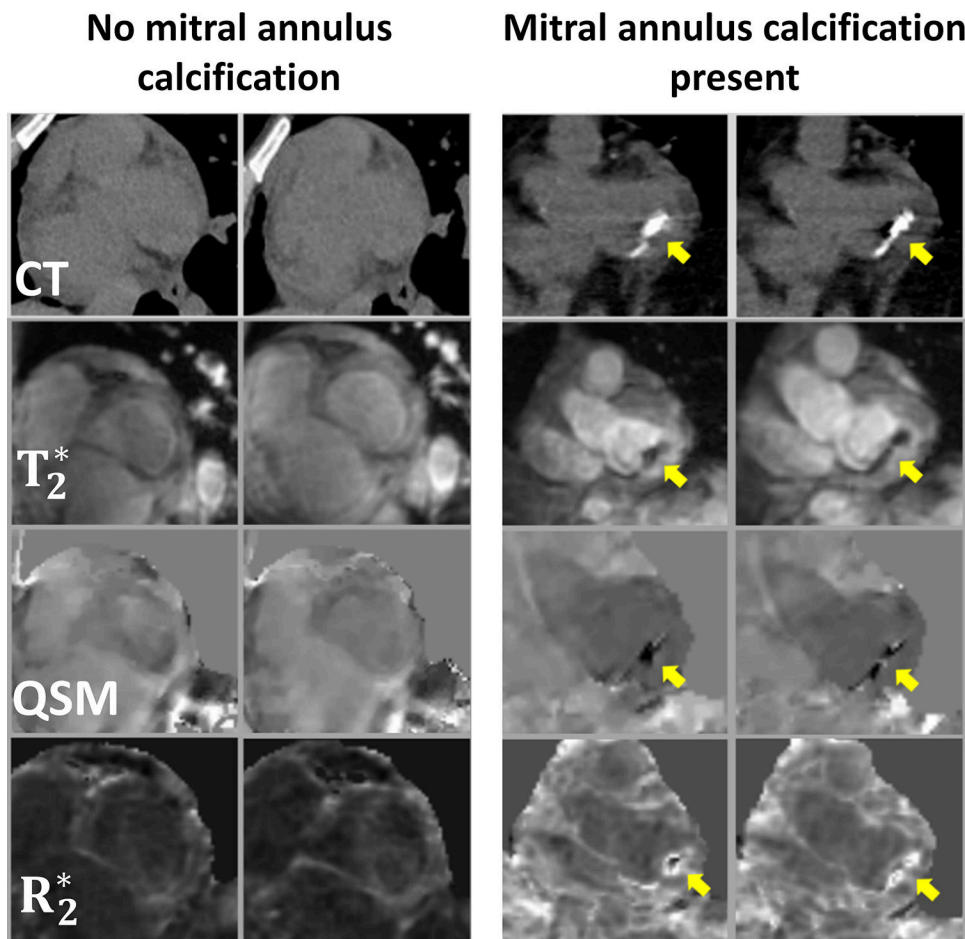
QSM of mitral calcification. Representative examples of patients with and without MAC as visualized by CT and T_2^* weighted magnitude, QSM, and R_2^* pulse sequences on cardiac MRI. Note that CT evidenced calcium was found to correspond with presence and location of annular susceptibility on cardiac QSM. Reprinted with permission from (133).
